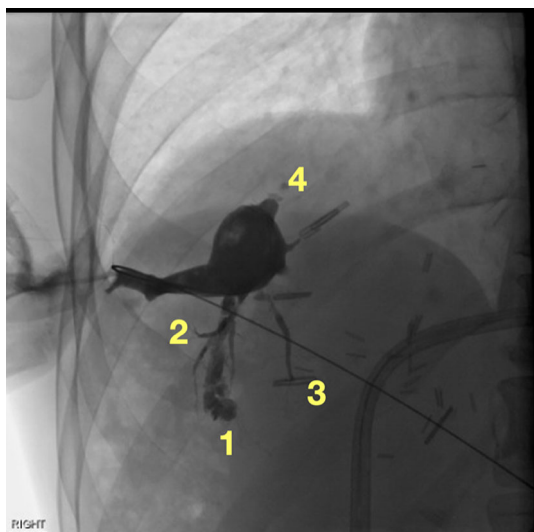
CT image showing four separate leaking ducts along hepatectomy margin
